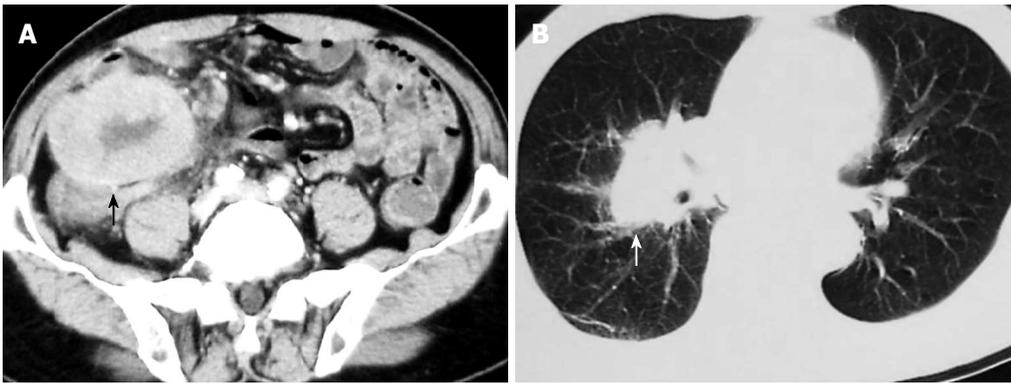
Computed tomography showing a large soft-tissue mass (black arrow) in the right lumbar region and iliac fossa (A) and a mass (white arrow) on the hilum of the right lung (B).
